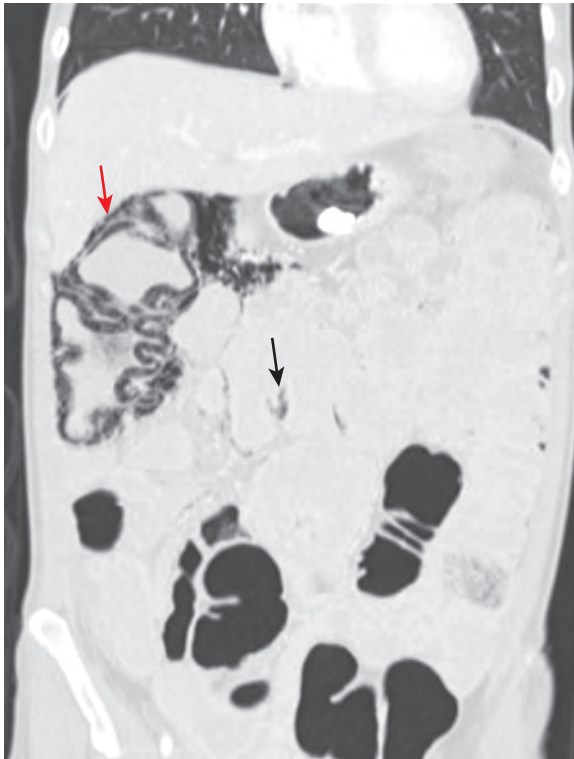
Colonic infarction with pneumatosis intestinalis and mesenteric venous gas: CT features. Coronal CT image shows pneumatosis (red arrow) in the region of the hepatic flexure of the colon and gas in the superior mesenteric vein (black arrow).
